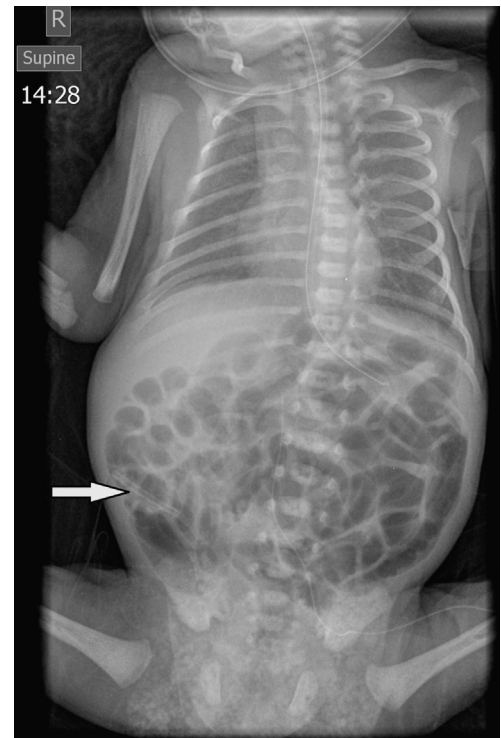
Anteroposterior abdominal X-ray shows the foreign body in the large intestine (Arrow points to the foreign body).
